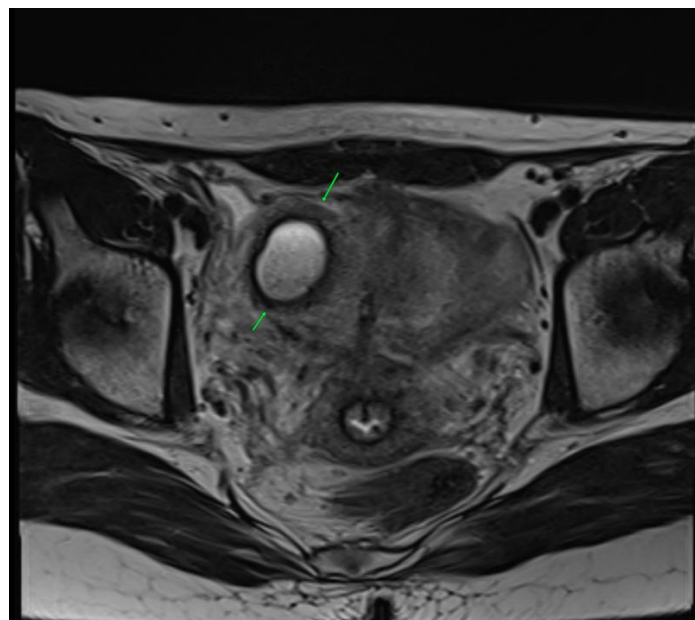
Axial T2-weighted magnetic resonance image showing a well-defined intramyometrial cavitory lesion in the right anterior myometrium displaying distinct internal T2 shading.
